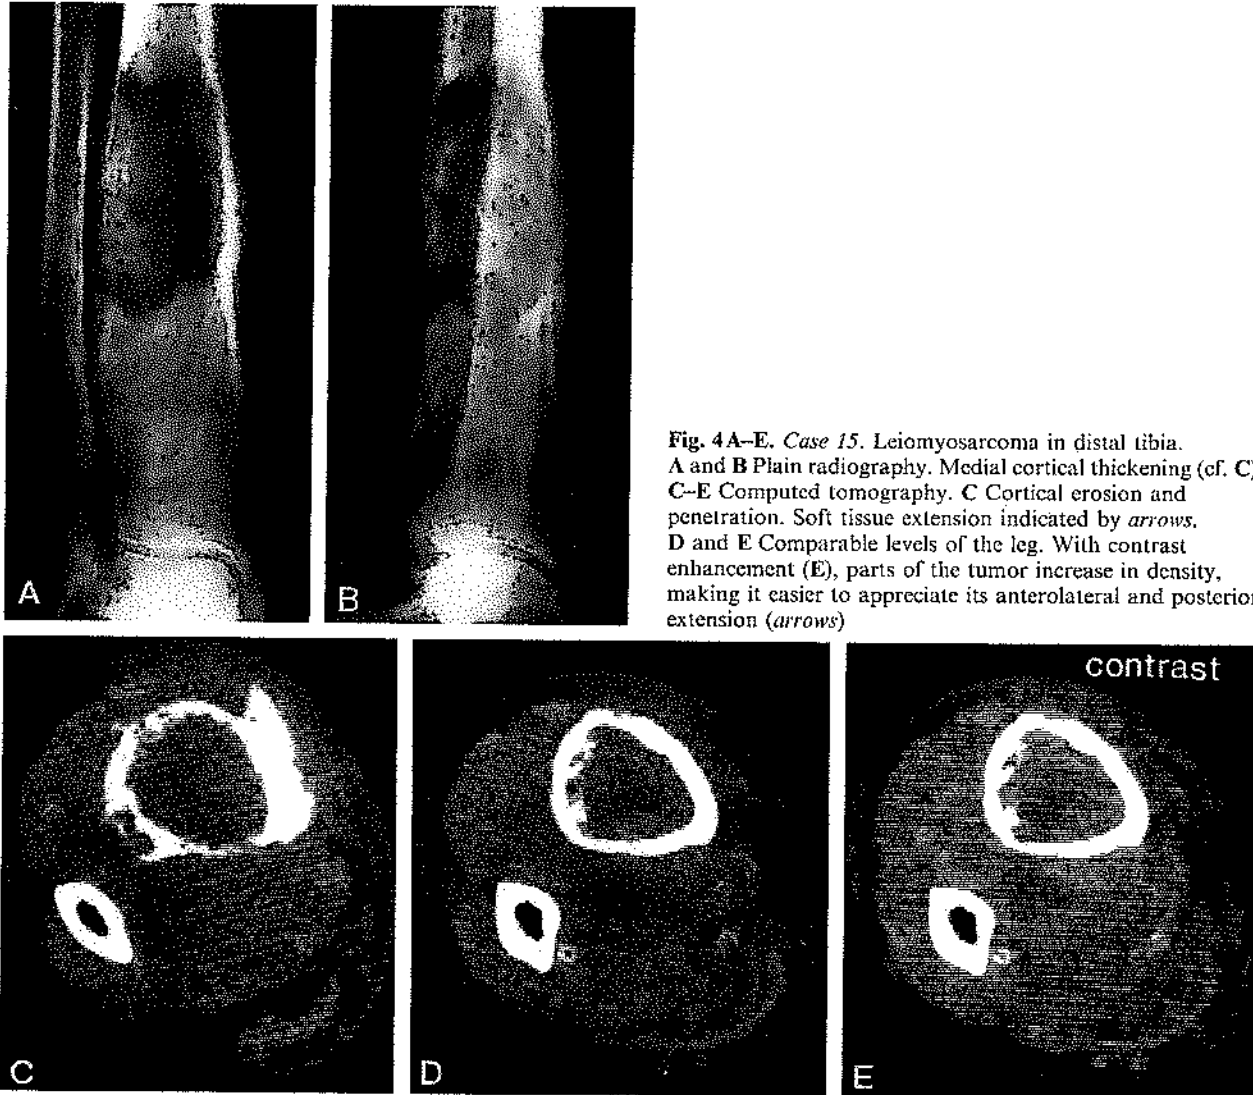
Case 15. Leiomyosarcoma in distal tibia. A and B Plain radiography. Medial cortical thickening (cf. C). C-E Computed tomography. C Cortical erosion and penetration. Soft tissue extension indicated by *arrows*. D and E Comparable levels of the leg. With contrast enhancement (E), parts of the tumor increase in density, making it easier to appreciate its anterolateral and posterior extension (*arrows*)
